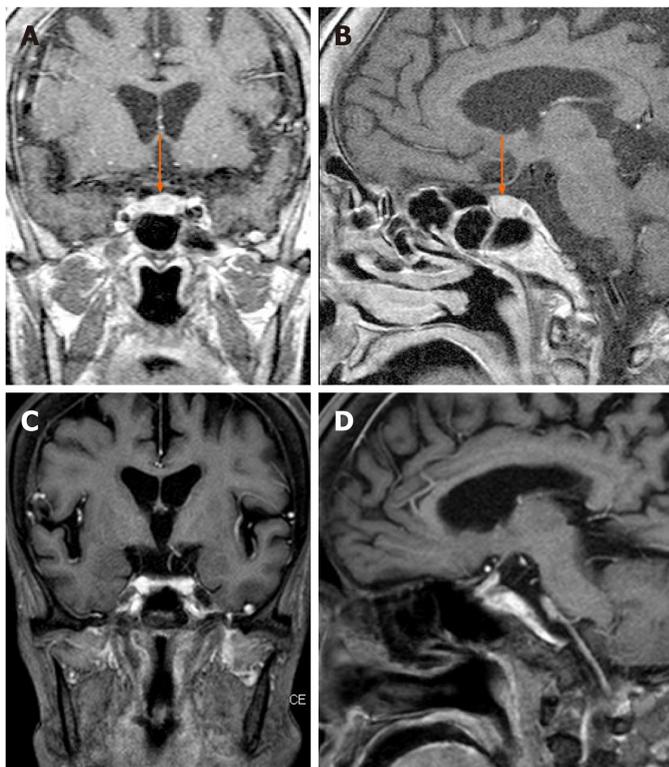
Magnetic resonance imaging: T1-weighted imaging. A and B: At presentation: coronary (A) and sagittal (B) view magnetic resonance images (MRI) showing an enlarged pituitary gland; C and D: Three months later (after the third cycle of chemotherapy): Coronary (C) and sagittal (D) view MRI showing substantial mass reduction.
